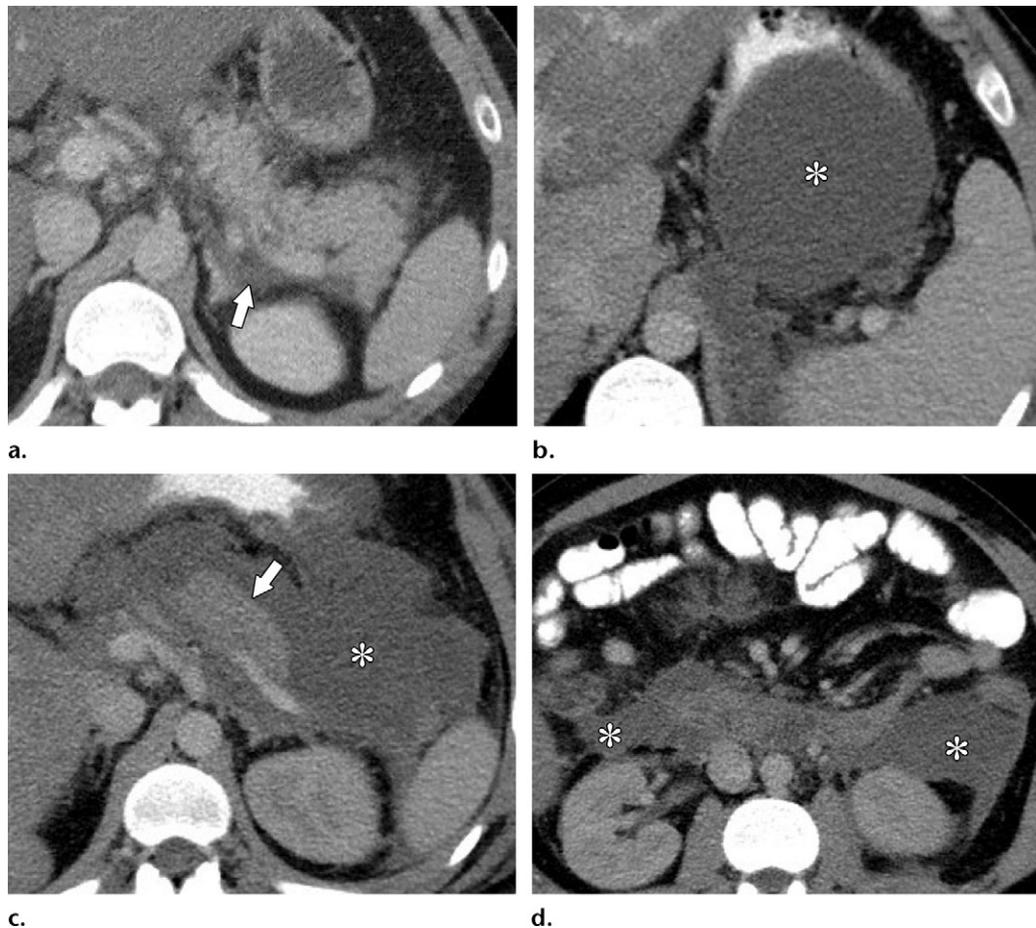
IEP with APFCs on axial contrast-enhanced CT images in a 49-year-old man. (a) One day after the onset of pain, IEP is seen with a small, homogeneous, fluid-attenuation collection in the left anterior pararenal space (arrow). The pancreas demonstrates normal enhancement. (b–d) At 10 days after onset of pain, multiple homogeneous fluid collections (*) can be seen in the lesser sac (b) and peripancreatic (c) and bilateral anterior pararenal spaces (d), findings consistent with APFCs. Arrow on c = normally enhancing pancreatic tail.
